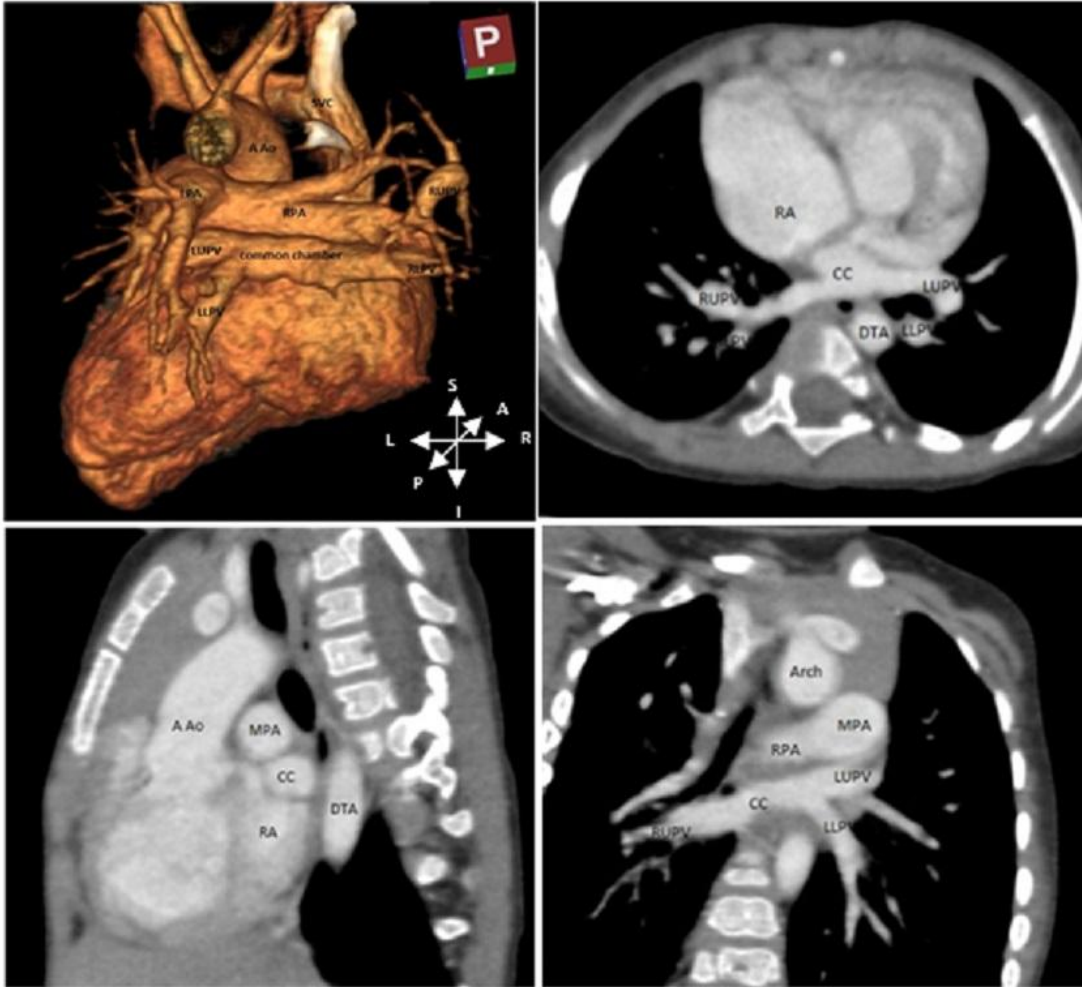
In clock wise order from left upper corner, volume rendered computed tomography image, transverse, coronal and sagittal sections revealing formation of common chamber (CC) by all four pulmonary veins behind small left atrium (LA) and below the pulmonary artery branches. This chamber in turn drains in to dilated right atrium (RA). A Ao- ascending aorta, Arch- aortic arch, DTA- descending thoracic aorta, LLPV- left lower pulmonary vein, LUPV- left upper pulmonary vein, RLPV- right lower pulmonary vein, RUPV- right upper pulmonary vein, SVC- superior vena cava.
